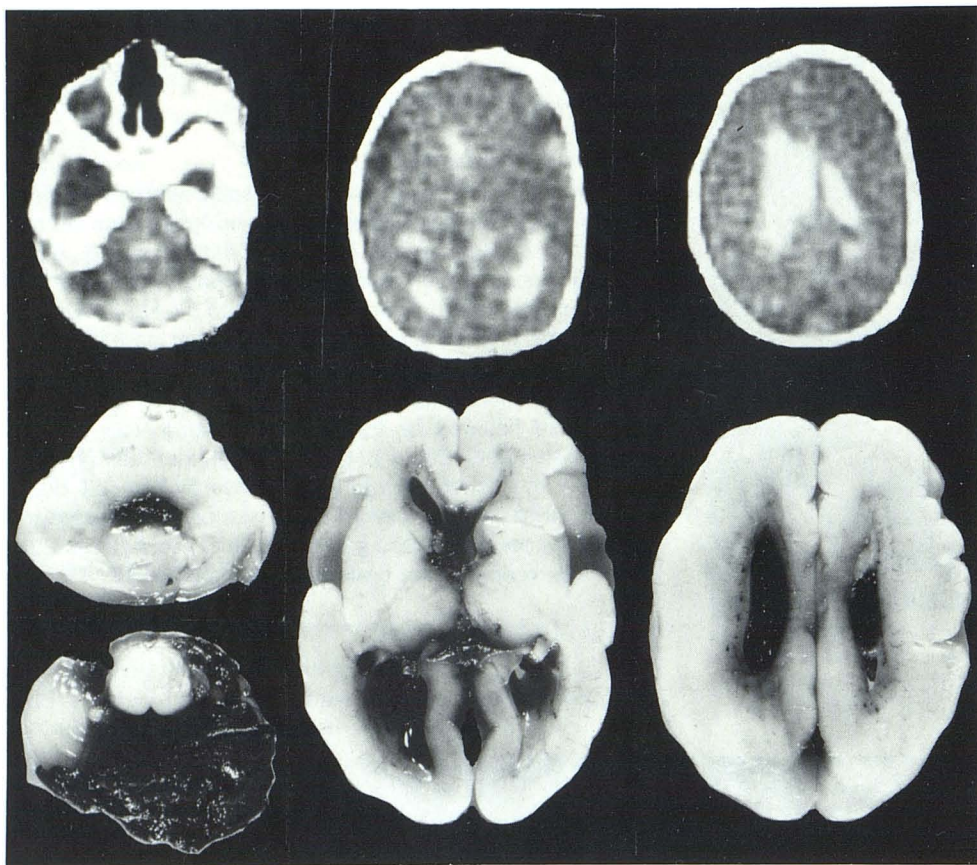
Subarachnoid, intracerebral, and intraventricular hemorrhage, stillborn infant, 24 weeks, birth weight 860 g. Interruption after radioiodine treatment in early pregnancy. CT: para- and intraventricular hemorrhage, hyperdensity in right sylvian fissure and retrocerebellar subarachnoid space. Autopsy: subependymal and intraventricular hemorrhage, secondary subarachnoid hemorrhage.
